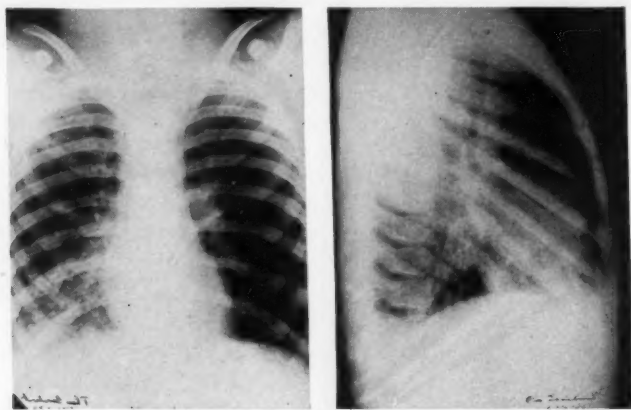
Case 4. Anteroposterior and right lateral Roentgenograms of a 10-year-old boy who had choked on a cough drop. The patchy soft tissue densities along the course of the bronchovascular markings from the right hilum to the right base are significant.
